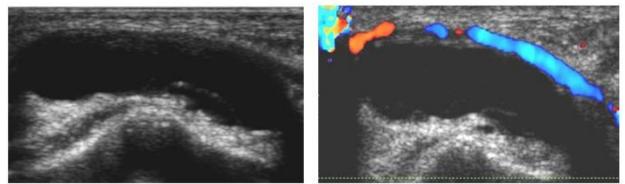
Volar Ganglion cyst associated with radial artery. (a) Longitudinal US image with Color Doppler showing a well defined cystic lesion in relation to the distal end of radius adjacent to and deviating the radial artery
